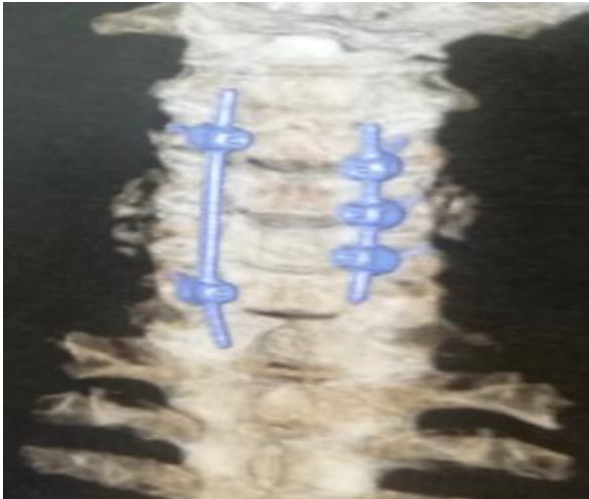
Postoperative CT 3D of the cervical spine posterior view showing failure of insertion of 2 screws due to violation of the lateral mass at those 2 levels while good placement of the other lateral mass screws. Rod system associated with laminectomy to decompress and fix cervical spine in 53 years old myelopathic female.
